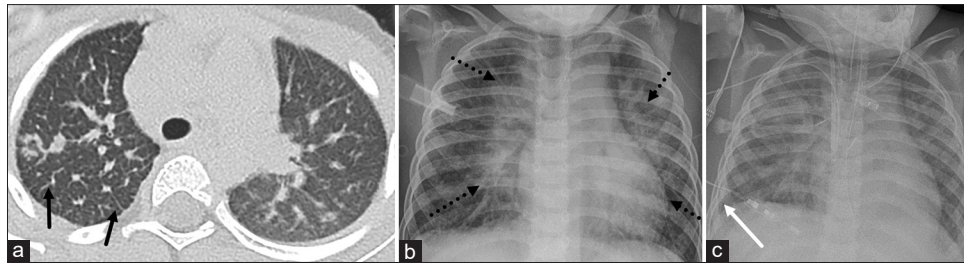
A 5-year-old male with Noonan syndrome. (a) Axial chest computed tomography image demonstrates interlobular septal thickening (black arrows) compatible with edema. (b) Next day chest radiograph shows worsening of perihilar predominant pulmonary edema (dashed black arrows). (c) Another chest radiograph performed hours later demonstrates worsening diffuse pulmonary edema, development of right-sided pleural effusion (white arrow) and interval placement of multiple lines and tubes including endotracheal tube
